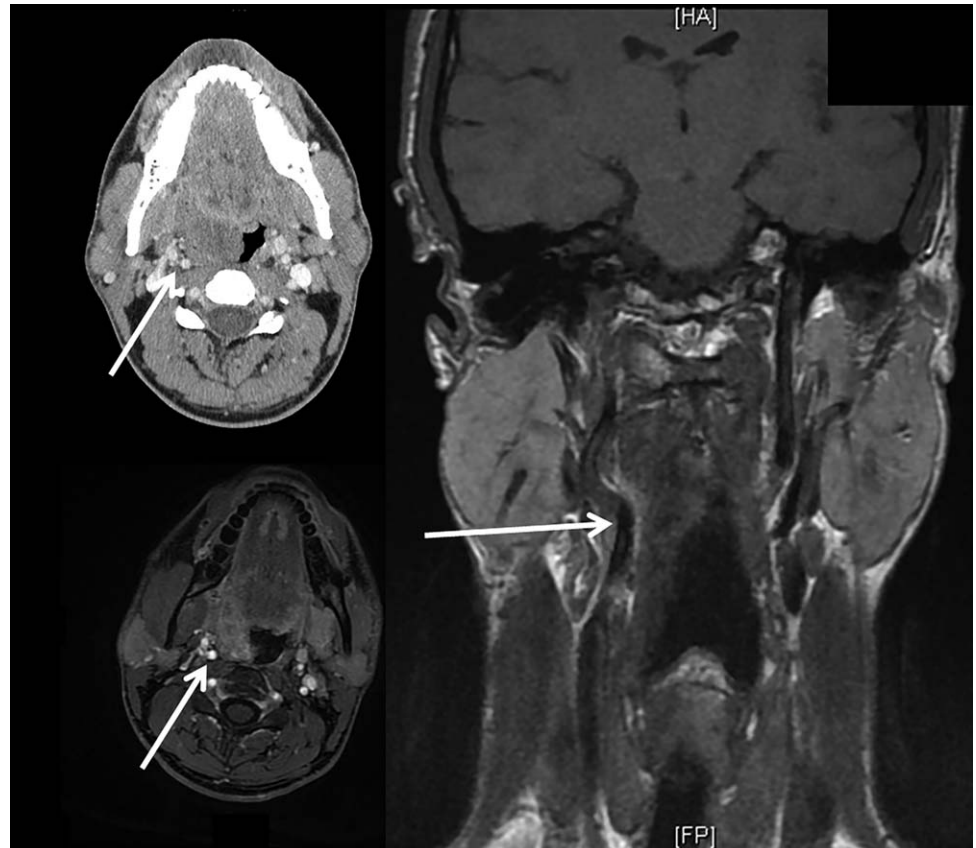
Preoperative MRI and CT scan of patient number 2, who presented with a 35-mm synovial sarcoma of the right tonsillar fossa. The internal carotid artery (ICA) formed a retropharyngeal loop that made contact with the deep limits of the tumor (white arrow). The patient underwent neoadjuvant chemotherapy followed by a complete transoral robotic surgery (TORS) resection via a cervical-transoral robotic approach with a free flap reconstruction.
